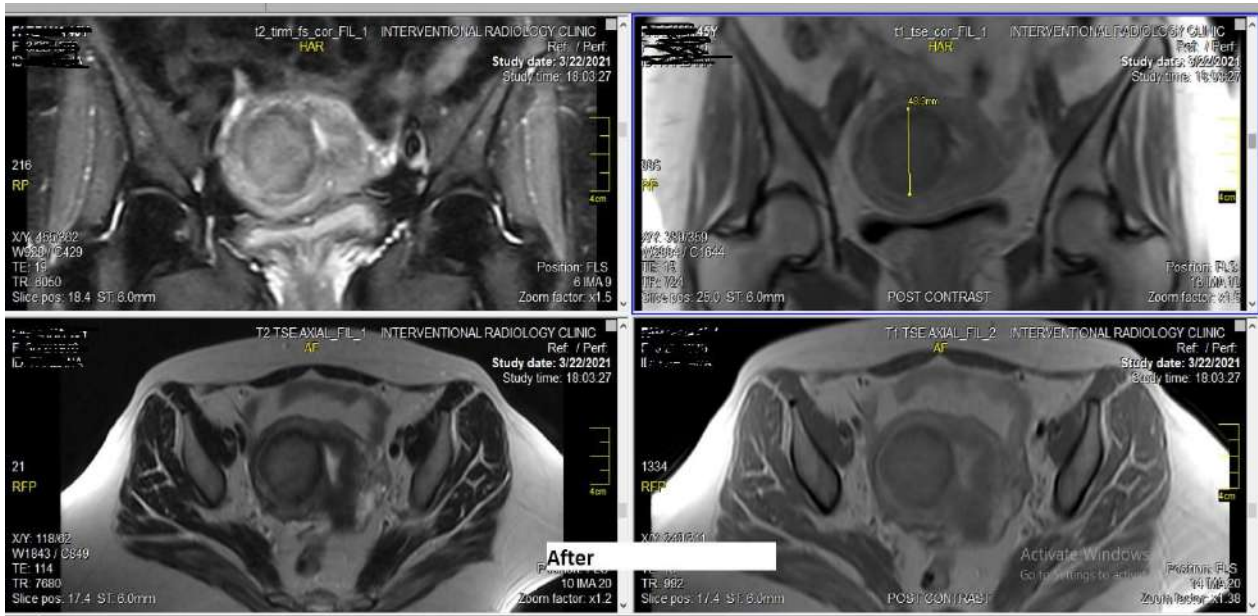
b: MR images following 3 months after embolization shows interval reduction in the size of fibroid and uterus.
